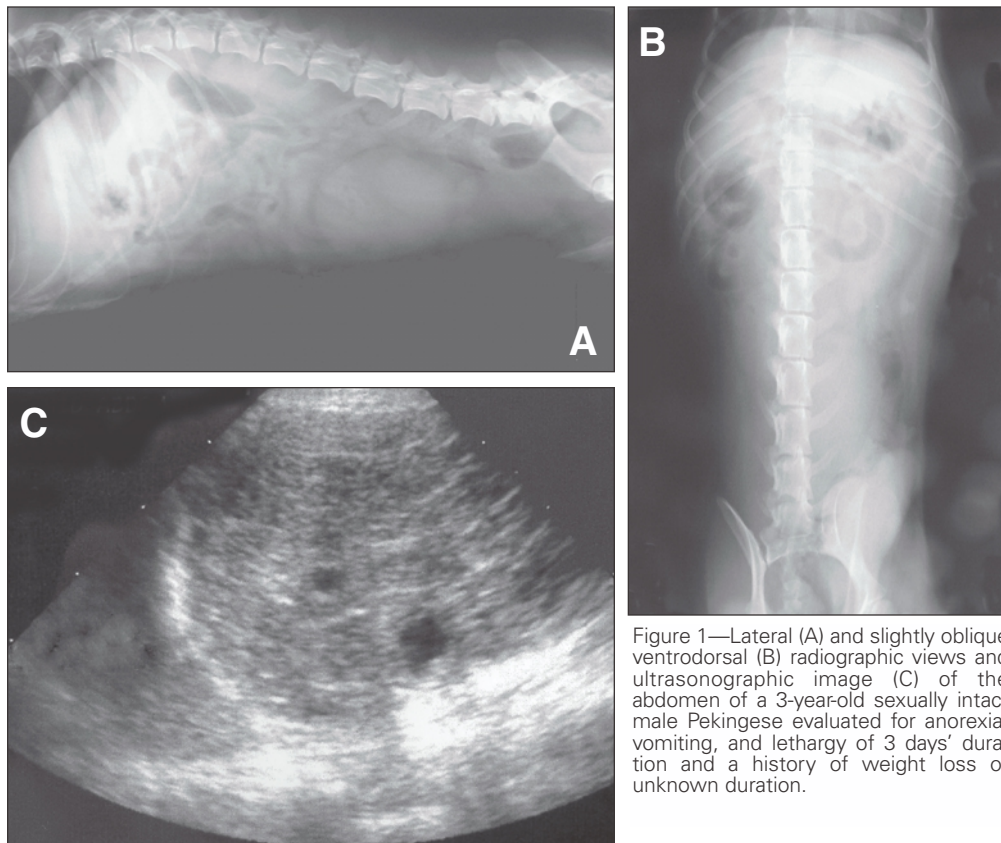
Lateral (A) and slightly oblique ventrodorsal (B) radiographic views and ultrasonographic image (C) of the abdomen of a 3-year-old sexually intact male Pekingese evaluated for anorexia, vomiting, and lethargy of 3 days' duration and a history of weight loss of unknown duration.
